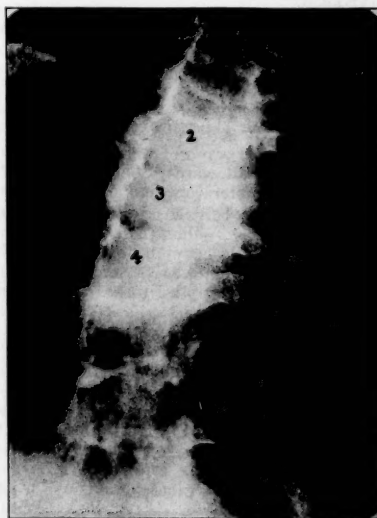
X-ray of upper dorsal spine showing an acute angulation of second and third dorsal vertebrae and an increased density of the bony parts.
